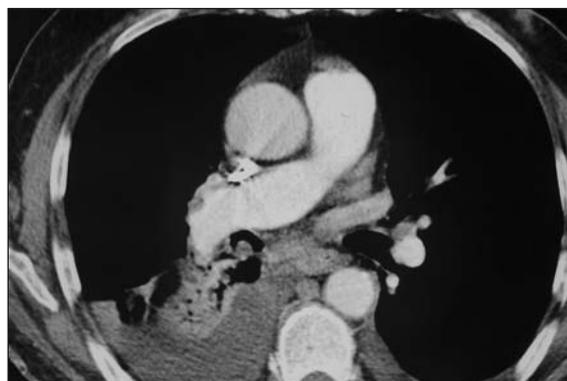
The view of thorax CT: Bilateral pleural effusion (massive in the right hemithorax), atelectasis of the right lower lobe, endobronchial lesion in the middle lobe.
